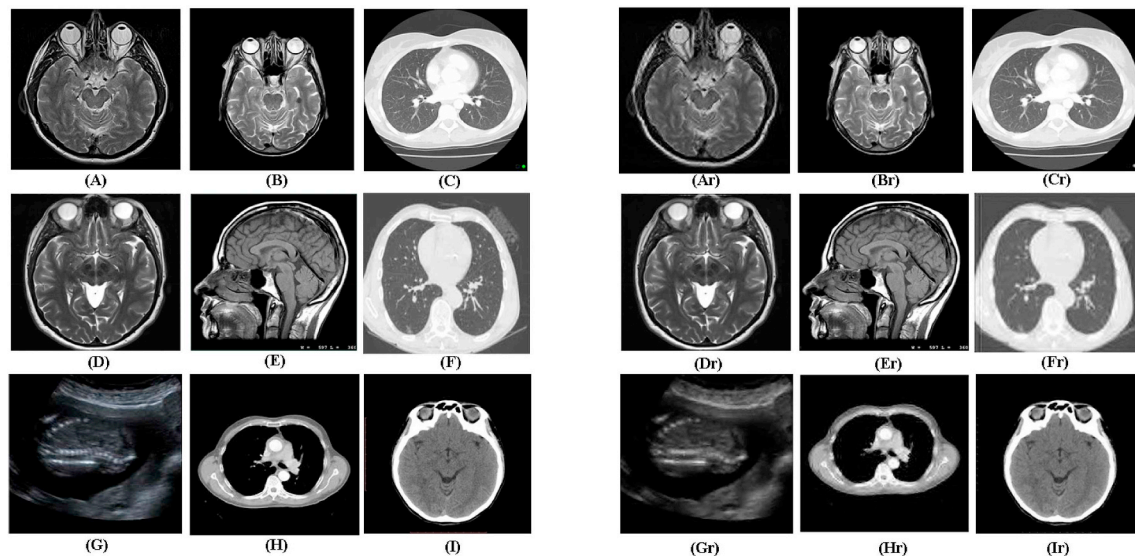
Selected images from DICOM and images in Table 6. (A) MRI brain at 3.0T, (B) MRI image of brain, (C) Axial lung, (D) MRI brain, (E) MRI of head showing the full brain from top, (F) Lung cancer diagnostic image, (G) Ultrasound fetal spine (H) CT chest scan, (I) MRI normal brain at 1.5T. The reconstructed images are: (Ar) for reconstructed of (A) etc.
